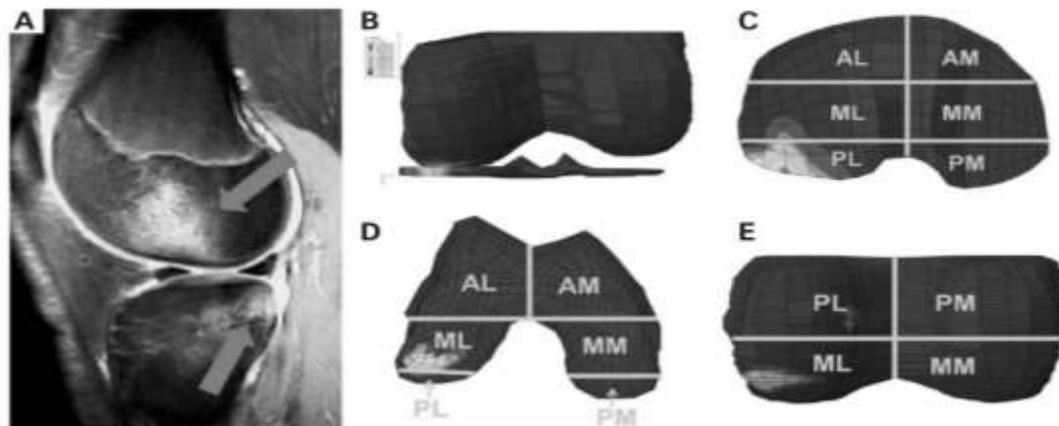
Magnetic Resonance Imaging of ACL Injury Loading Mechanism . Adapted from "The anterior cruciate ligament injury controversy: is "valgus collapse" a sex-specific mechanism?," by C.E. Quatman and T.E. Hewett, 2009.
